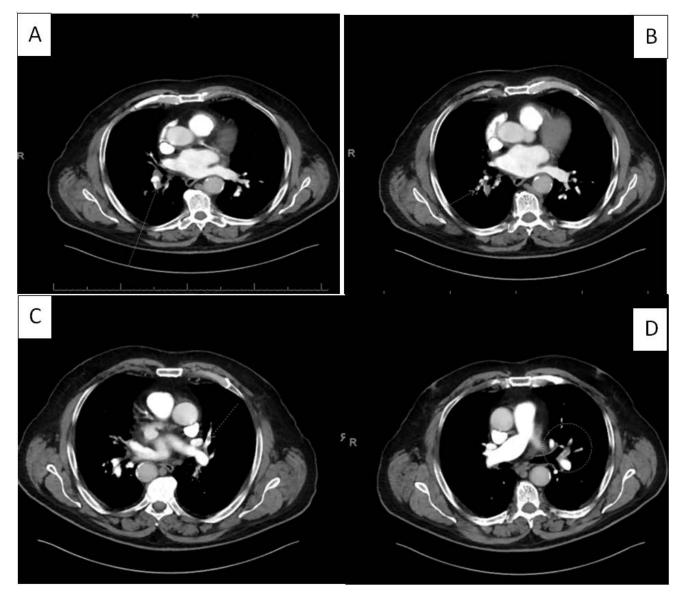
CTA of the chest showing bilateral pulmonary embolism
